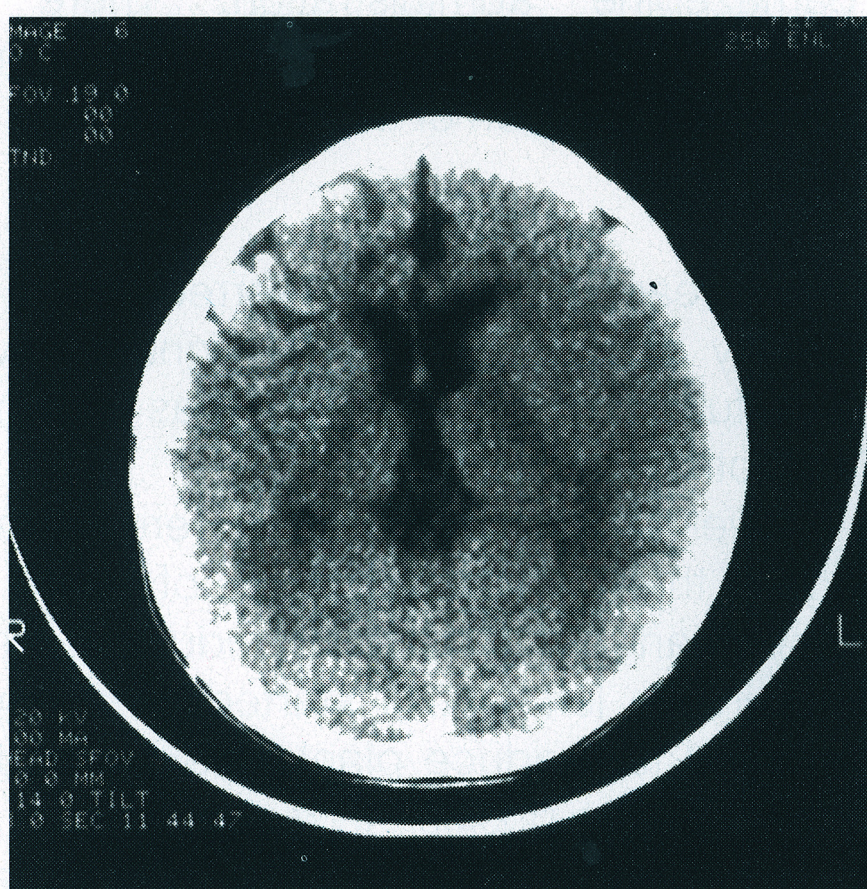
A brain CT of Patient 1 revealed diffuse frontoparietal atrophy.
